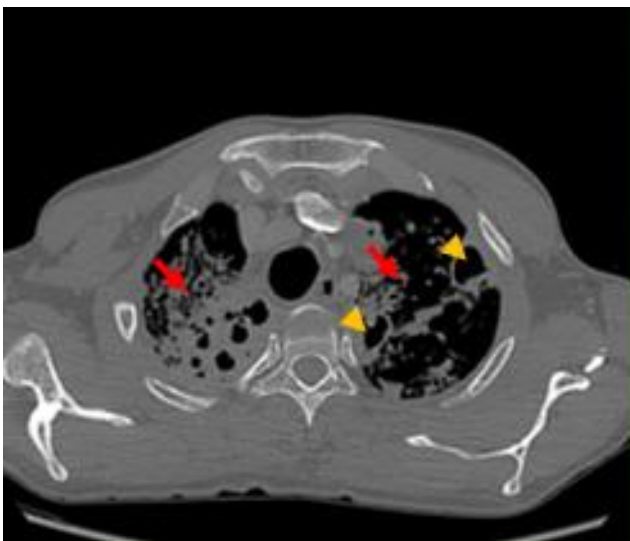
Computed Tomography of the neck with lung apices showing heterogenous opacities with parenchymal destruction (arrow) and cavitary lesions (arrowhead)
